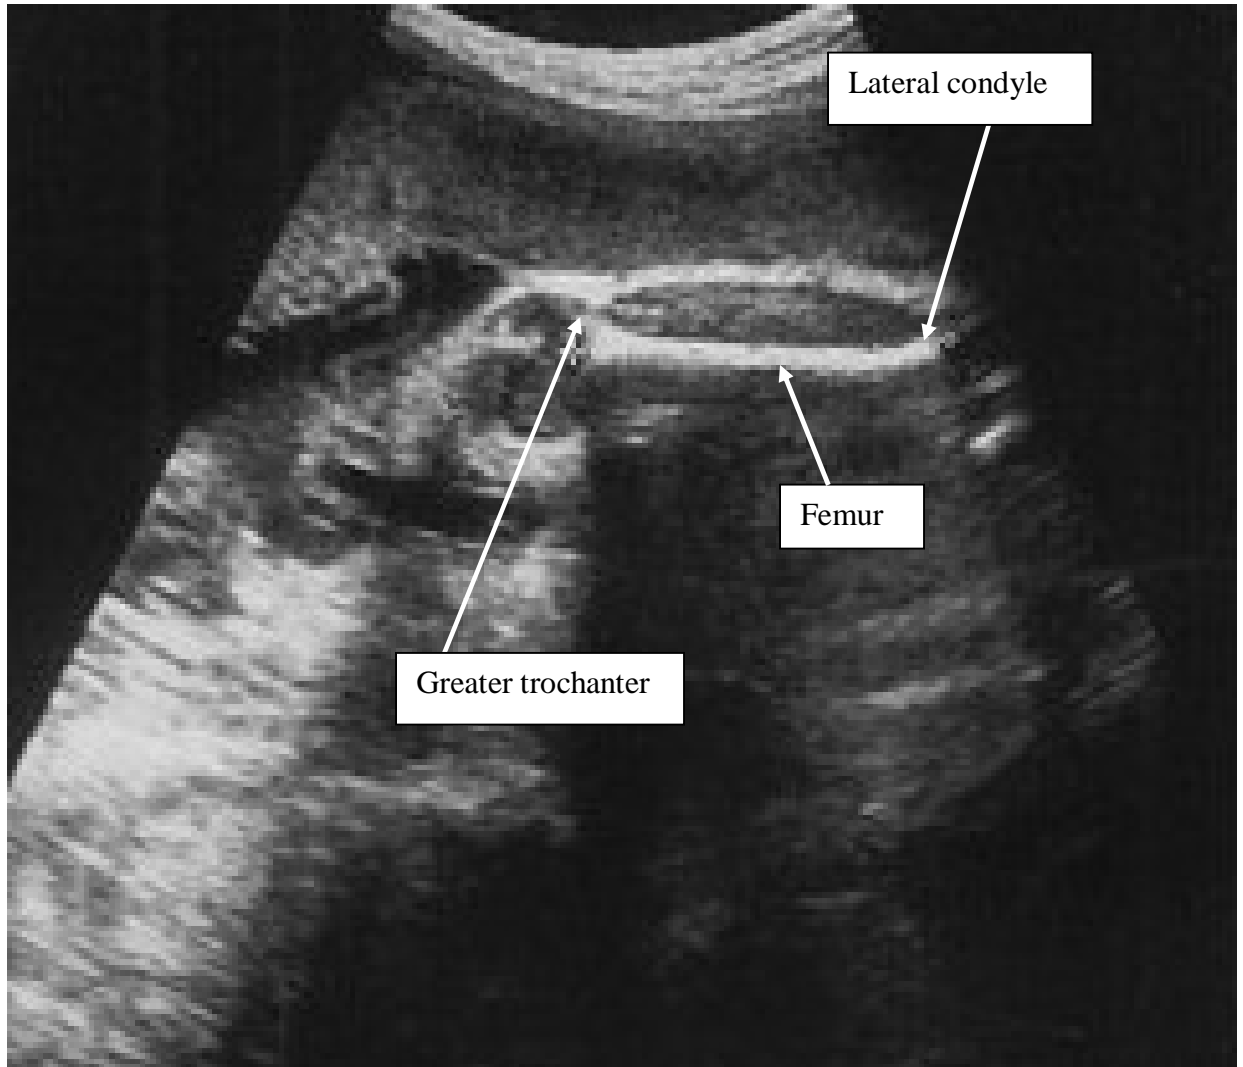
An ultrasound image of the thigh of the fetus showing the fetal femur
